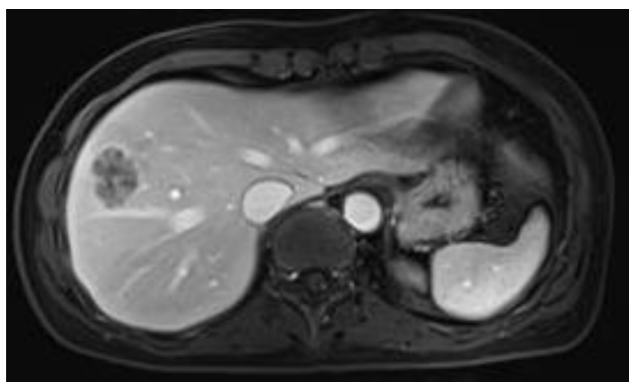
T1-weighted MRI during the portal phase depicting a lesion with low signal intensity and uneven internal signal in the upper segment of the right anterior lobe (S8) (axial view)
